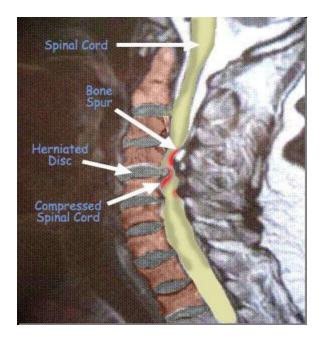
MRI of the neck showing multilevel compression of the spinal cord.¹⁵
